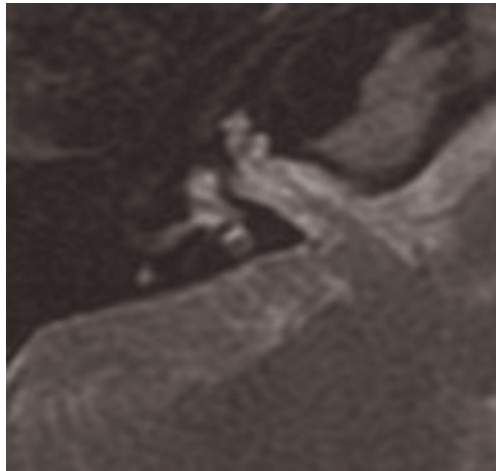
T2-weighted axial MR image: 'cochleovestibular hypoplasia'.
